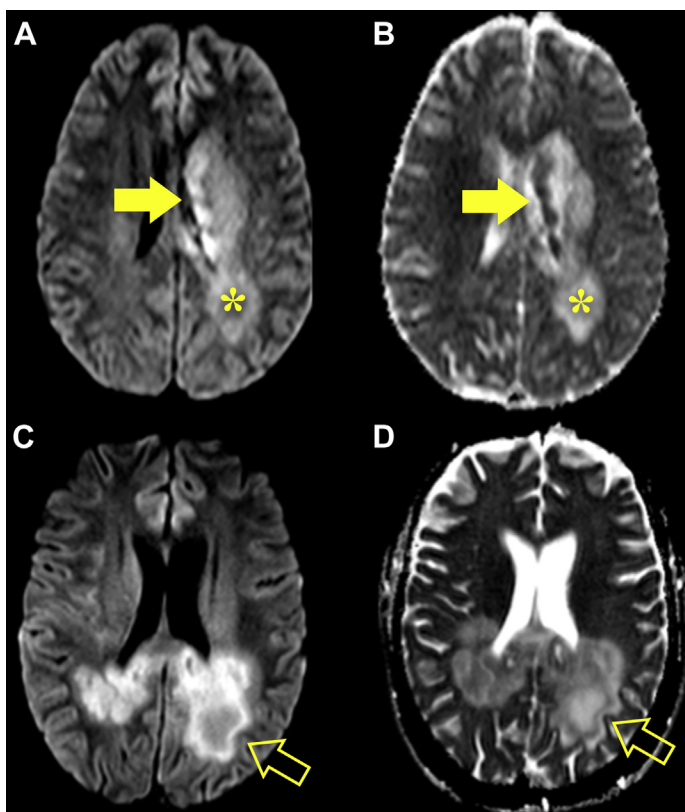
Central nervous system lymphoma with foci of restricted diffusion (arrows) as shown on DWI (A) and ADC (B) along the left caudate and splenium, and extensive surrounding edema that demonstrates T2 shine-through (asterisks). (C, D) Tumefactive demyelination involving the splenium and periventricular white matter, with a thin rim of restricted diffusion along a front of active demyelination (arrows). Note the relative paucity of surrounding edema and mass effect despite a larger lesion in the case of tumefactive demyelination.
